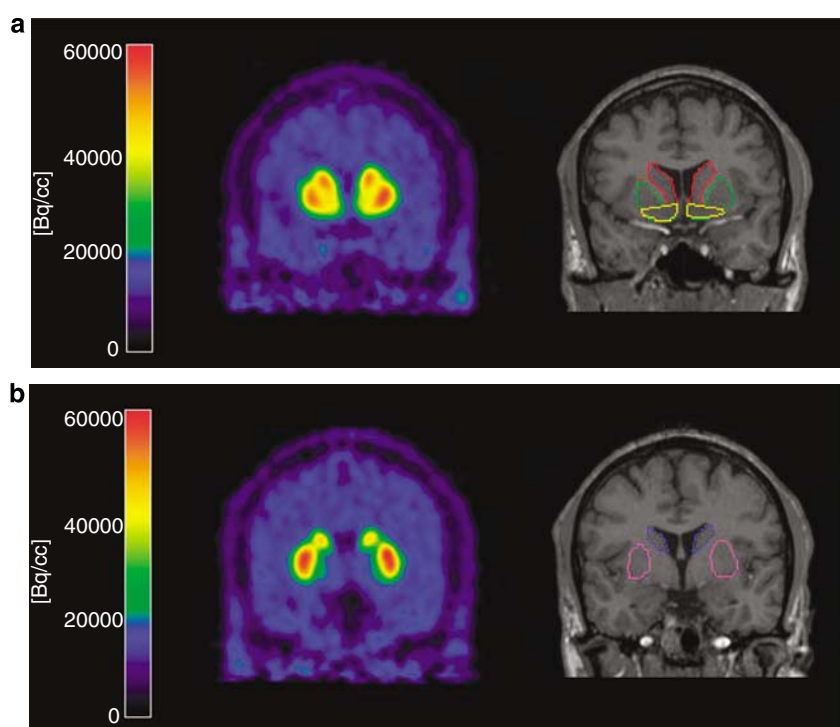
Coronal slices of (left) PET [^{11}C]raclopride and (right) co-registered magnetic resonance imaging (MRI) scans at the level of the striatum, (a) anterior and (b) posterior to the AC-plane. Striatal subregions are indicated on the MRI scans: ventral striatum (yellow), precommissural dorsal putamen (green), precommissural dorsal caudate (red), postcommissural putamen (purple), and postcommissural caudate (blue).
